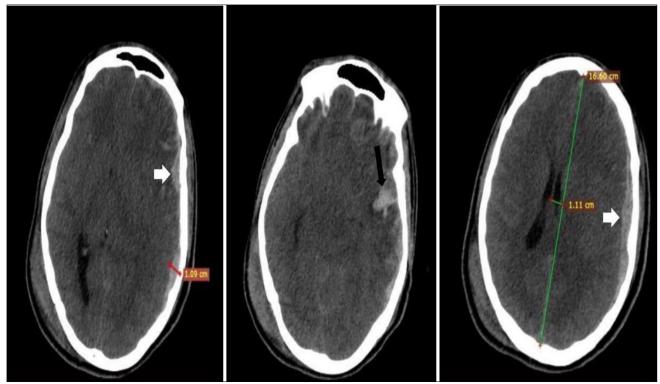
Cerebral CT scan performed on admission, axial sections, parenchymal window: left fronto-parieto-temporal subdural haematoma (white arrow), intraparenchymal haematoma (black arrow)
